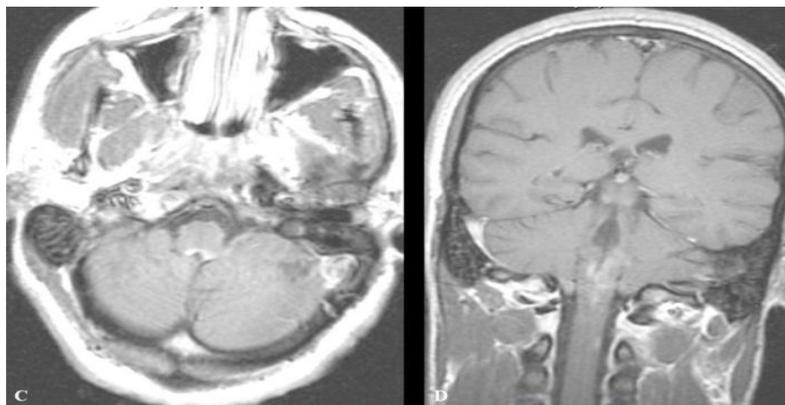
Magnetic resonance imaging of the head. Sagittal T1 images without contrast (A) and with contrast (B) revealing contrast-enhancing lesion in the posterior aspect of the lower medulla (arrow).
